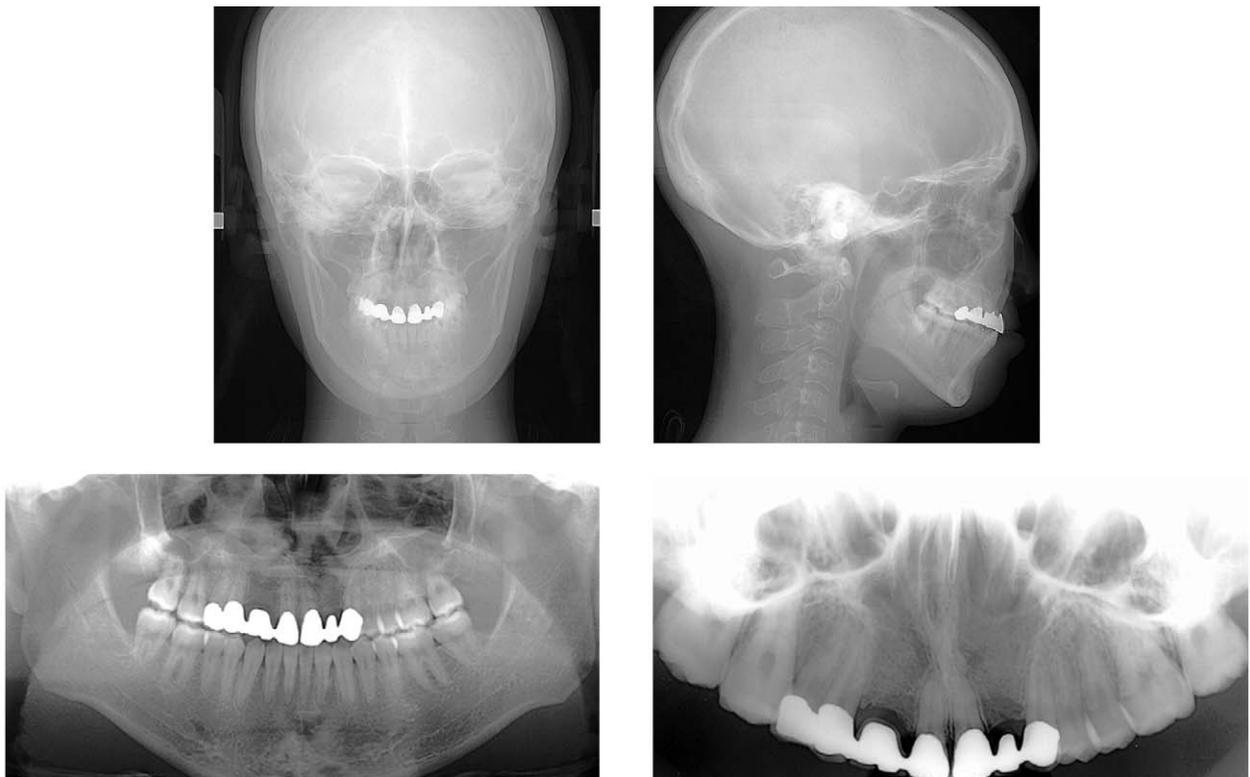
Radiographs after secondary bone graft and prosthetic treatment.
